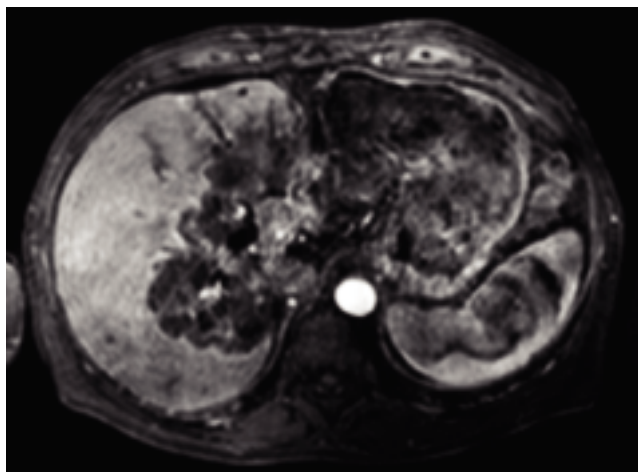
Contrast-enhanced MRI of the liver with the intrahepatic cholangiocarcinoma (three months after treatment), showing partial response according to the EASL criteria.
